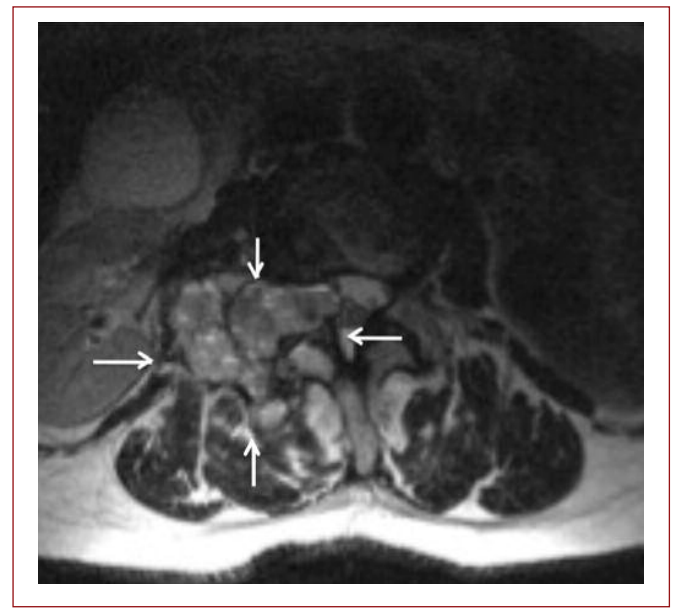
Axial T1-weighted MRI of case 2 showing lesions with many fluid-fluid levels.
